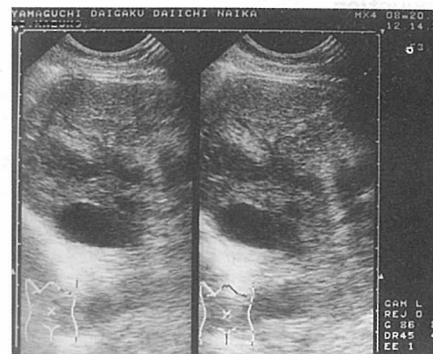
Ultrasonography on admission. Some focal high and low echoic lesions were shown in the right lobe of the liver.
